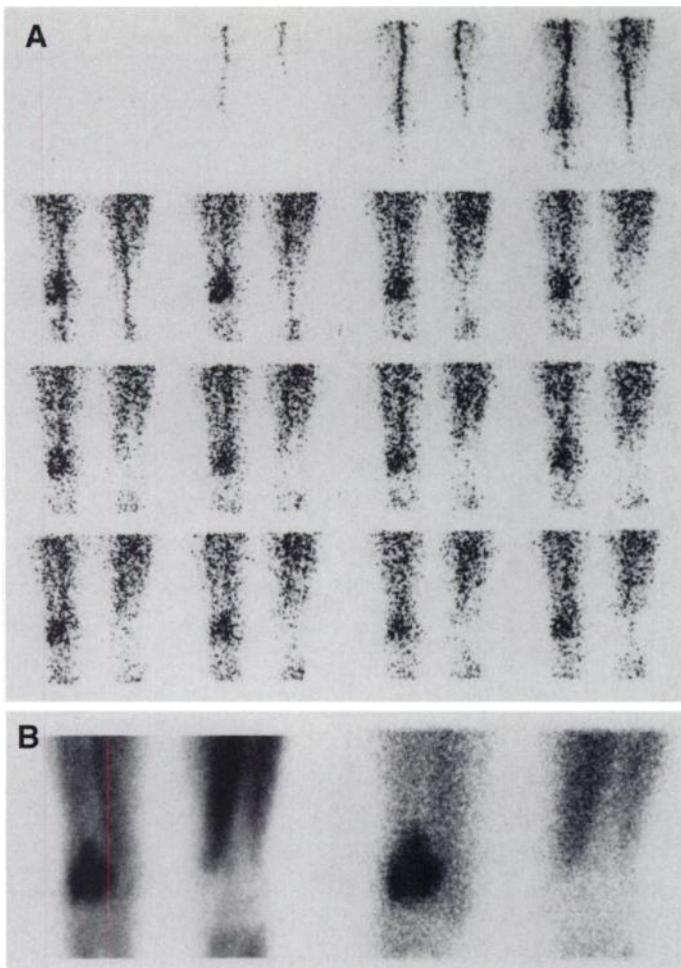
A 67-yr-old woman with malignant fibrous histiocytoma in the right distal femur (Patient 13). (A) Radionuclide angiography with ^{99m}Tc -MIBI shows markedly increased tumor perfusion in the right distal femur. (B) Both ^{99m}Tc -MIBI (left) and ^{201}Tl (right) scintigraphy show intense accumulation in the lesion. In this patient, muscle uptake was greater with ^{99m}Tc -MIBI than ^{201}Tl .
